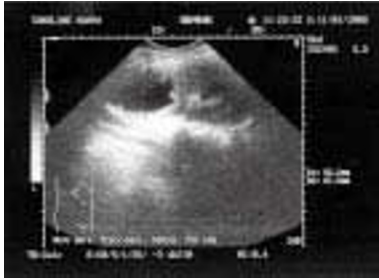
Ultrasonography revealed a unique right kidney with a cystic unilocular tumor.
